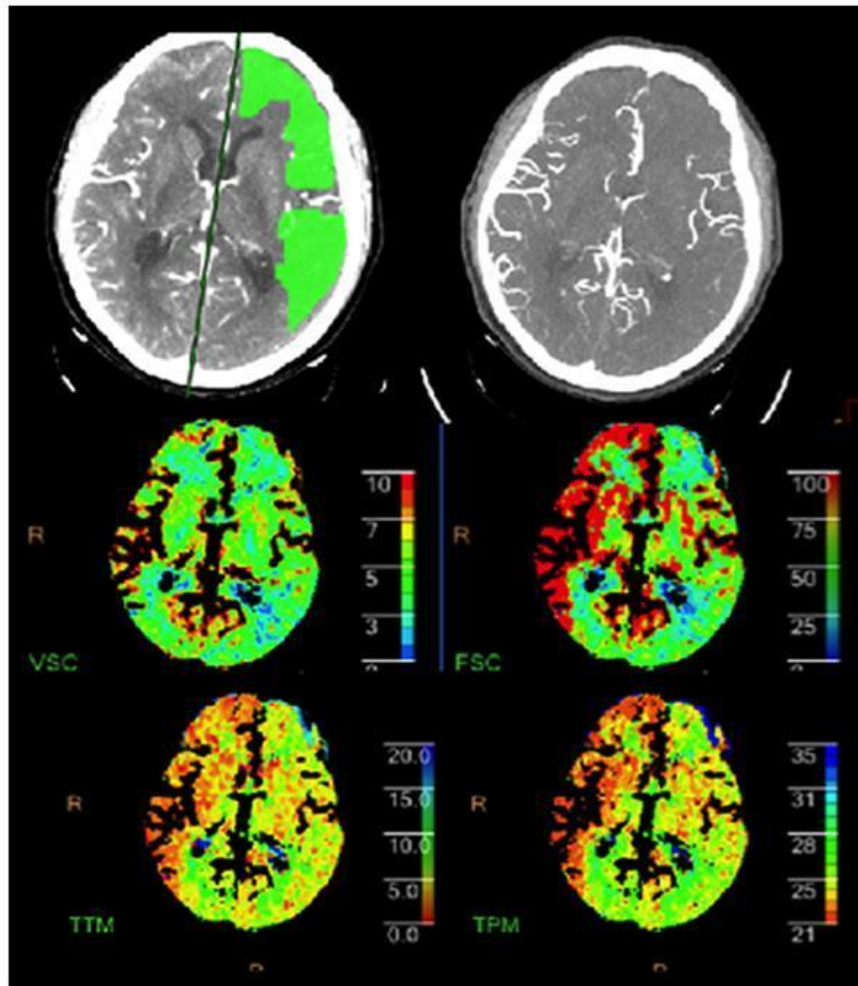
(top left). PCT prediction map showing false "ischemic penumbra" in the left lobe. Figure2 (top right). Increased right lobe vascularity in CTA. Figure3 (bottom). PCT colour maps revealing decreased MTT and increased CBF in the right lobe.
